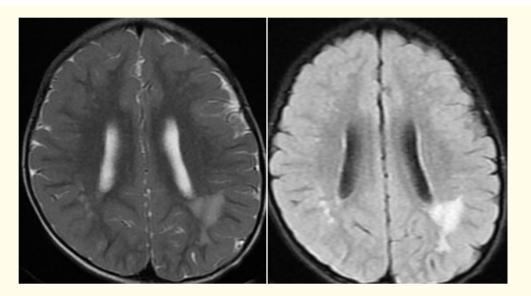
MRI Brain T2 and FLAIR showing periventricular leukomalacia.
